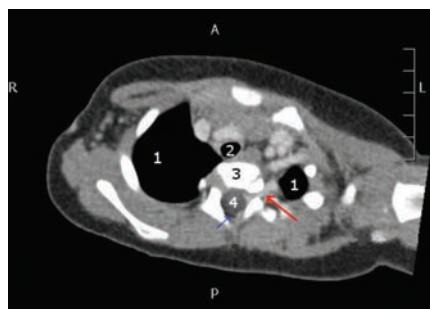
Computed tomography scanner after intra-venous injection of iodinated contrast medium showing a left enhanced and dilated paravertebral vascular structure with intraforaminal, intraspinal and extradural extension (red arrow). 1: Lung; 2: aorta; 3: vertebra; 4: medulla; blue arrow: epidural space.
